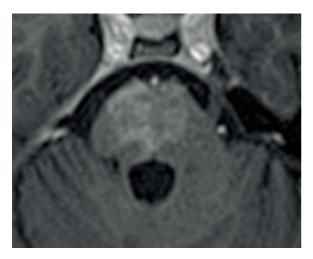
Contrast-enhanced T1 skull MRI. Enhancement at the pontine base denoting subacute infarction.
